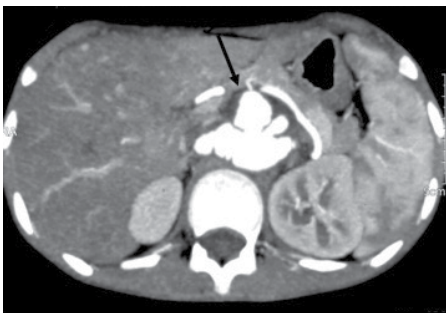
Transverse cuts of contrast enhanced computed tomography of the abdominal vessels show multiple aneurysms at the origin of the renal arteries (arrow)
